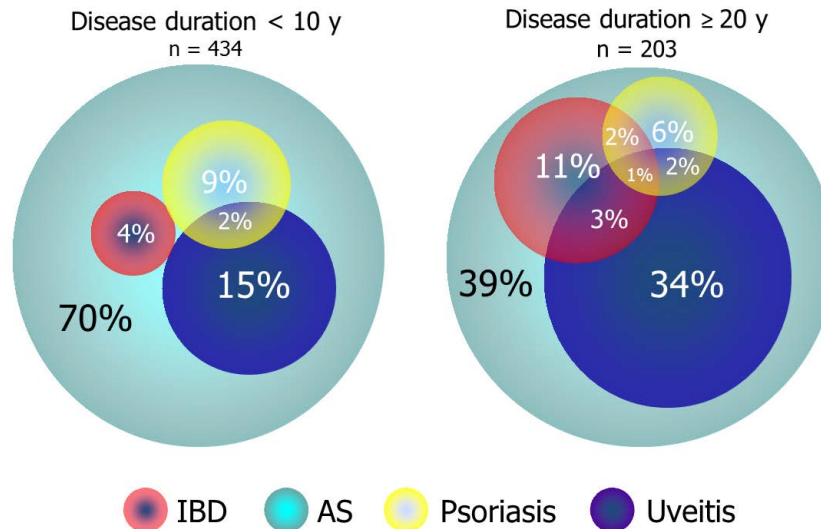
Proportion of AS patients with a history of extra-articular manifestations over time in the ASPECT study population. From the ASPECT study, unpublished data.
